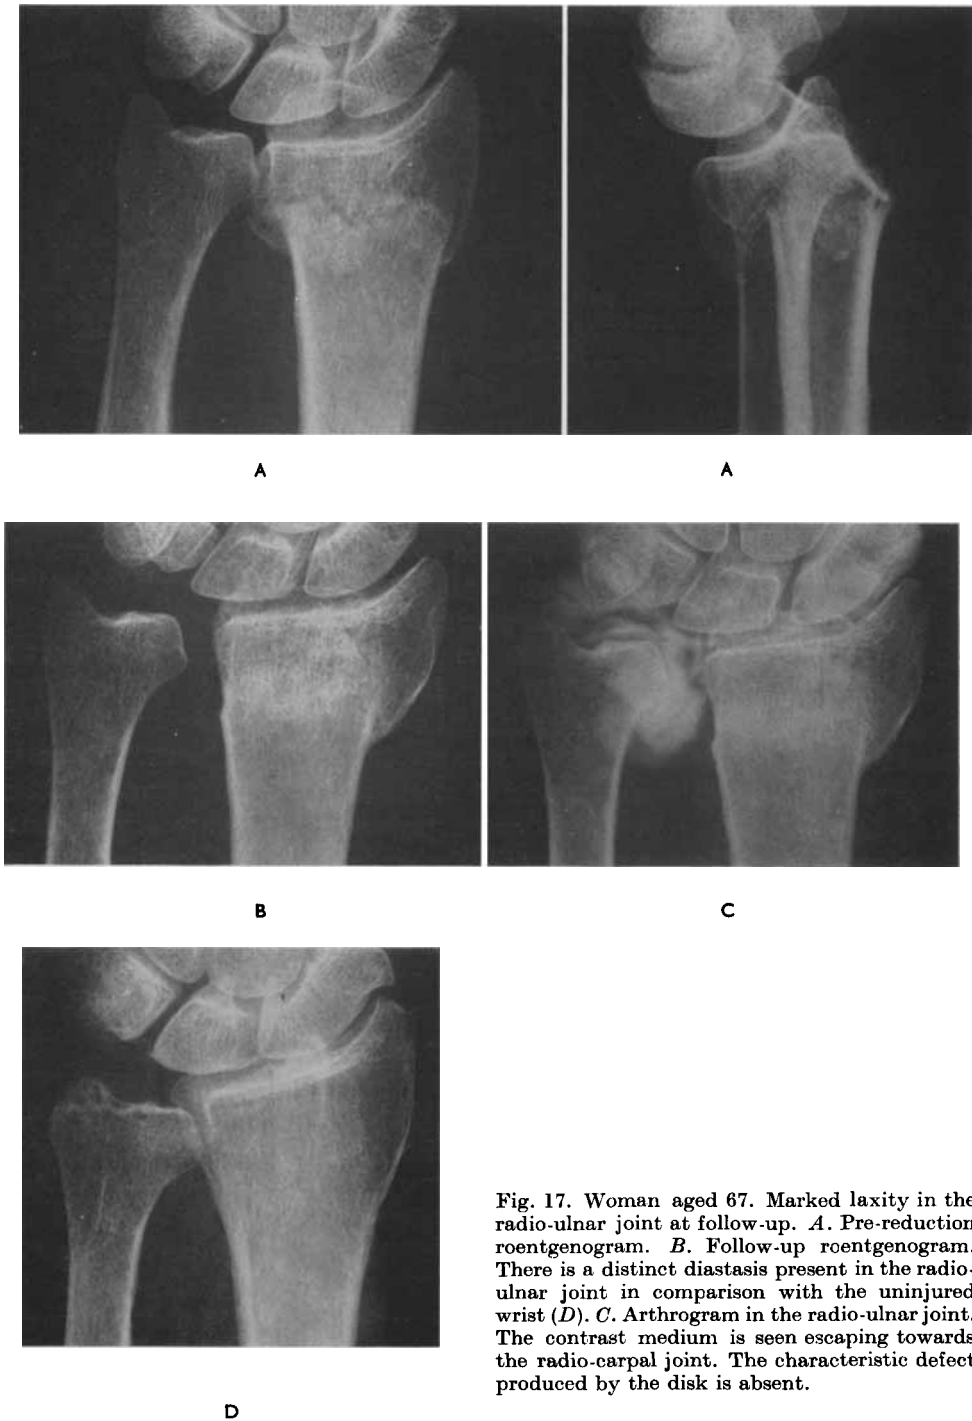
Woman aged 67. Marked laxity in the radio-ulnar joint at follow-up. *A.* Pre-reduction roentgenogram. *B.* Follow-up roentgenogram. There is a distinct diastasis present in the radio-ulnar joint in comparison with the uninjured wrist (*D*). *C.* Arthrogram in the radio-ulnar joint. The contrast medium is seen escaping towards the radio-carpal joint. The characteristic defect produced by the disk is absent.
